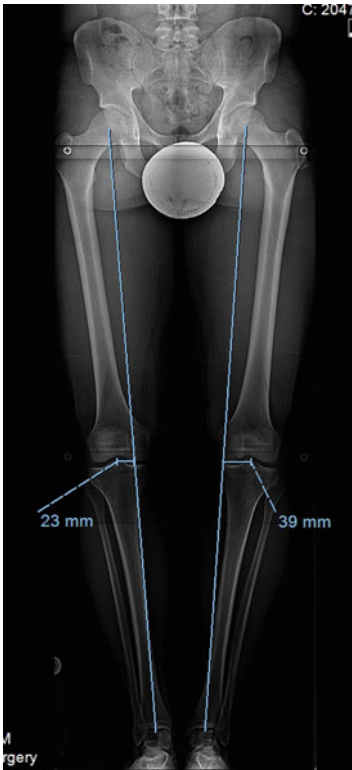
51" standing, bipedal radiograph shows bilateral medial mechanical axis deviations (39 mm medial on *left* and 23 mm medial on *right*)
